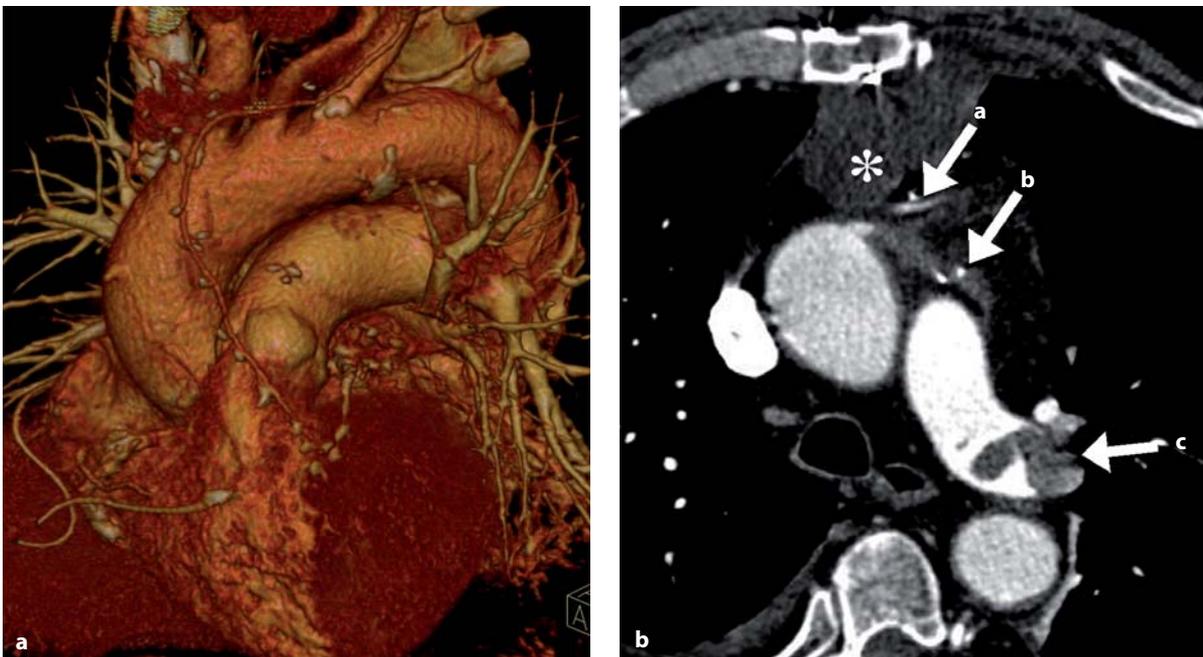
a, b. Shortly after bypass surgery, this patient was referred for CT to evaluate his chest pain. The CT shows a retrosternal hematoma (*asterisk*). Thrombosed venous (a) and patent arterial (b) bypass graft as well as thrombus formation in the pulmonary artery (c) were detected
